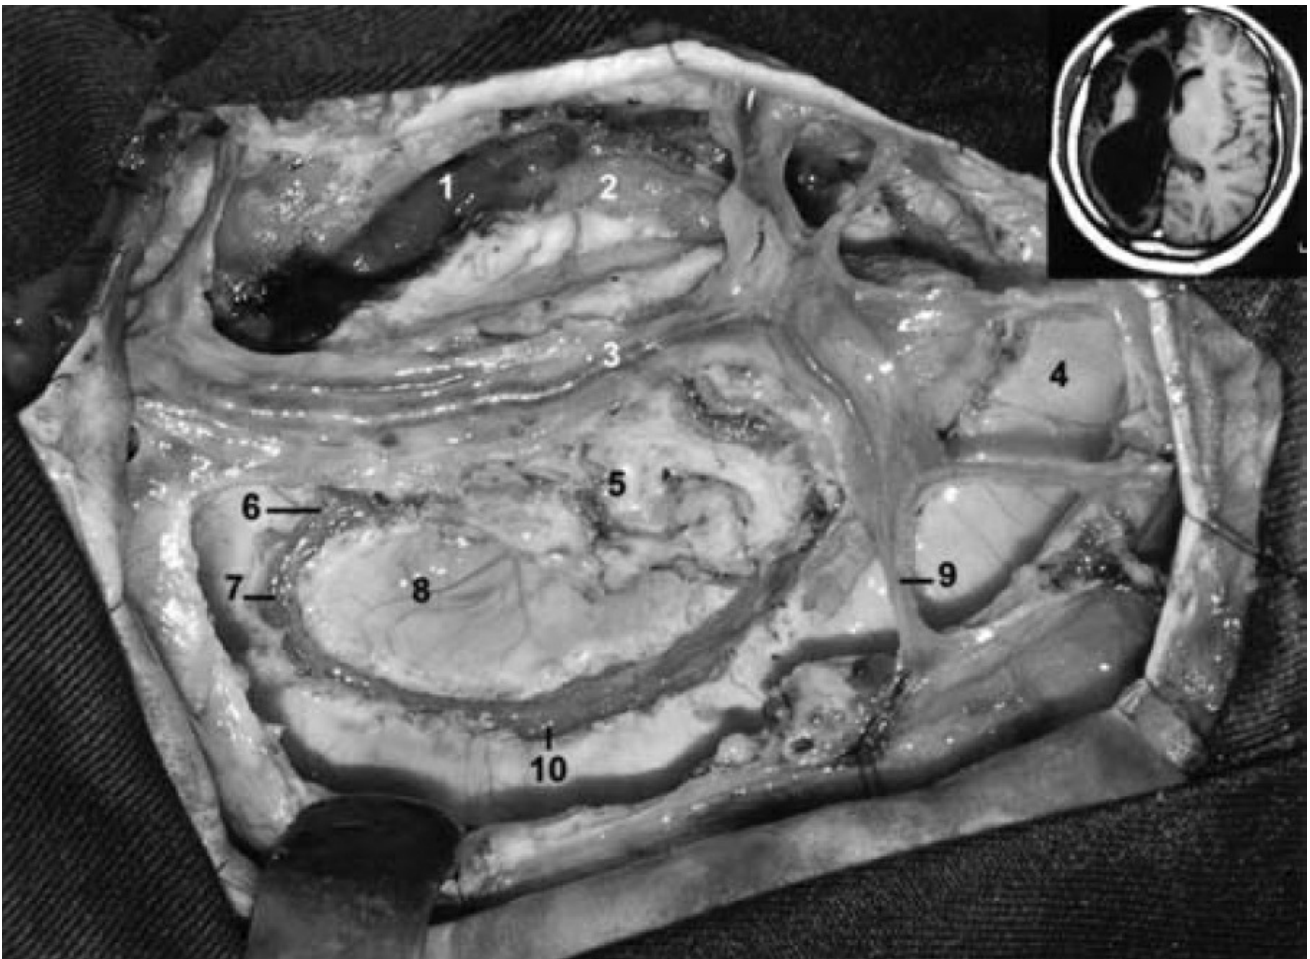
Intraoperative photograph obtained in a patient with extreme ventriculomegaly, showing the trajectory of the intraventricular callosotomy from the splenium to the rostrum. *Inset:* Preoperative MR image. 1 = arachnoid membrane of the floor of the middle fossa after selective amygdalohippocampectomy; 2 = choroid plexus of the temporal horn; 3 = superficial sylvian vein; 4 = atrium; 5 = central core; 6 = ACA under the rostrum of the corpus callosum; 7 = ACA ahead of the genu of the corpus callosum; 8 = septum pellucidum; 9 = branch of the MCA; 10 = ACA above the body of the corpus callosum. (Image courtesy of AL Rhoton, Jr.)
